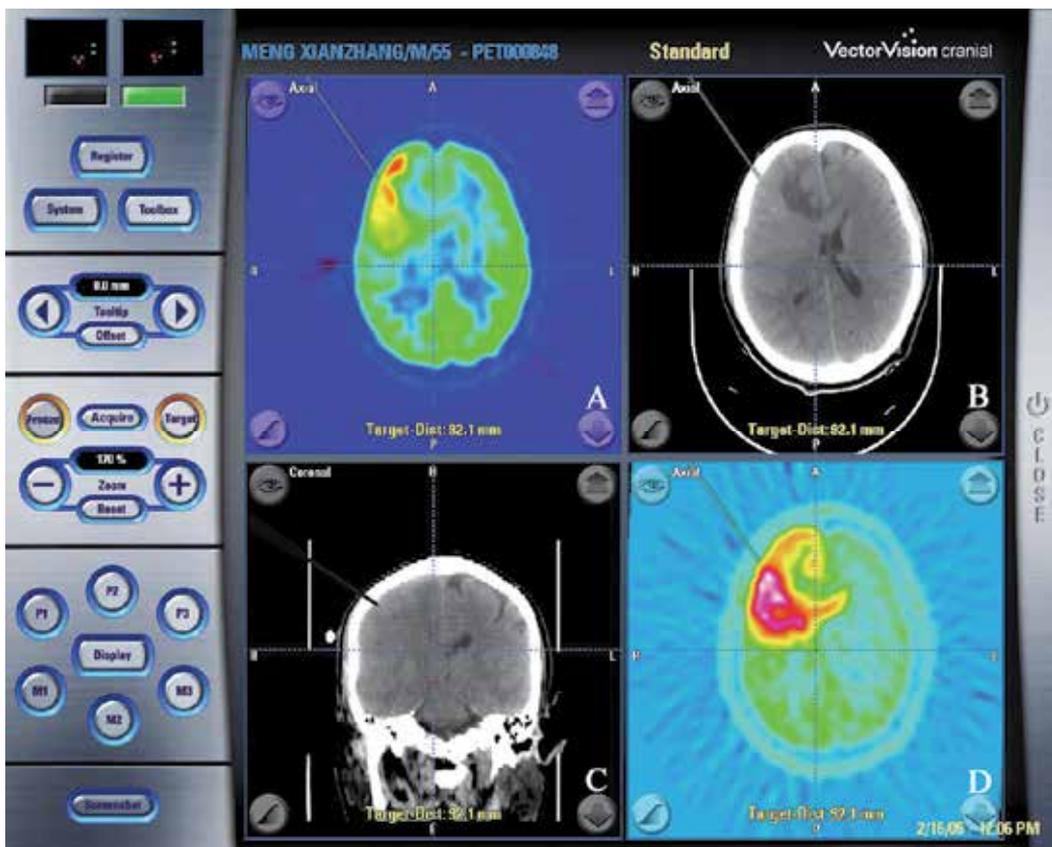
Positron emission tomography (PET) neuronavigation system monitoring images captured during the operation. A: ^{18}F -fluorodeoxyglucose PET scan; B, C: CT scans; D: ^{11}C -methionine PET scan. CT provided the anatomic background. PET provided more distinct information of the tumor.
